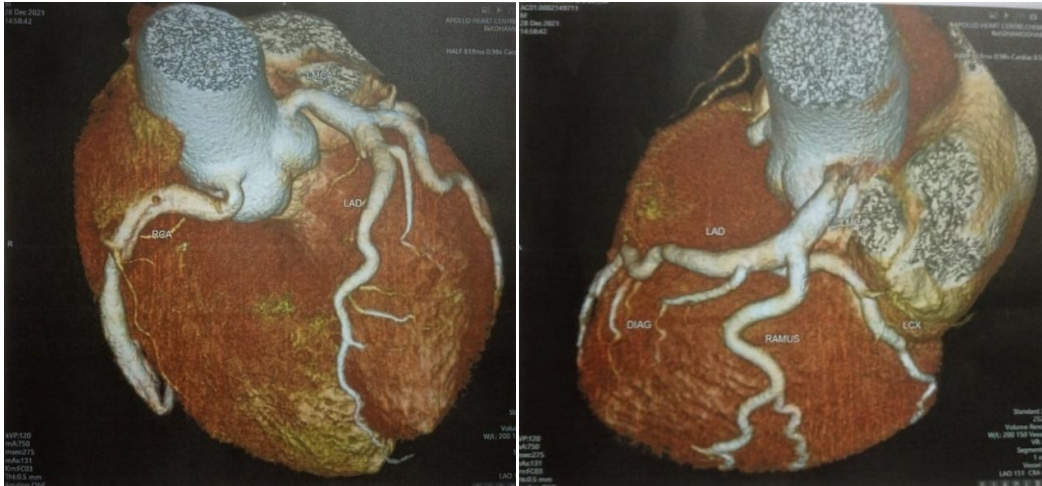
CT coronary angiogram
